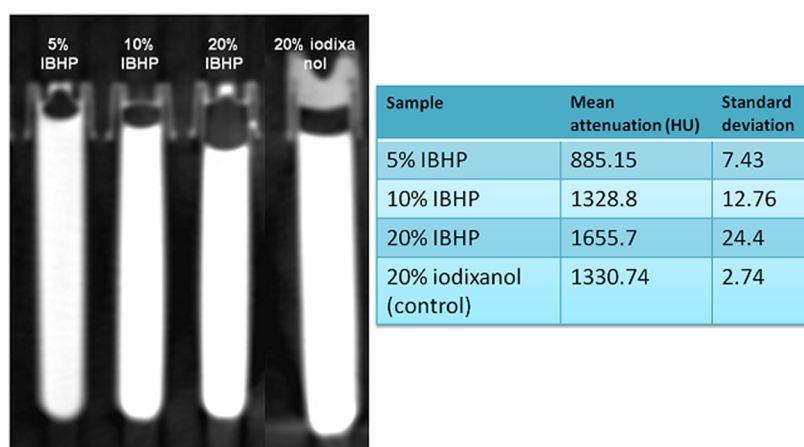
X-ray opacity of different concentrations IBHP and control material (20% iodixanol).
